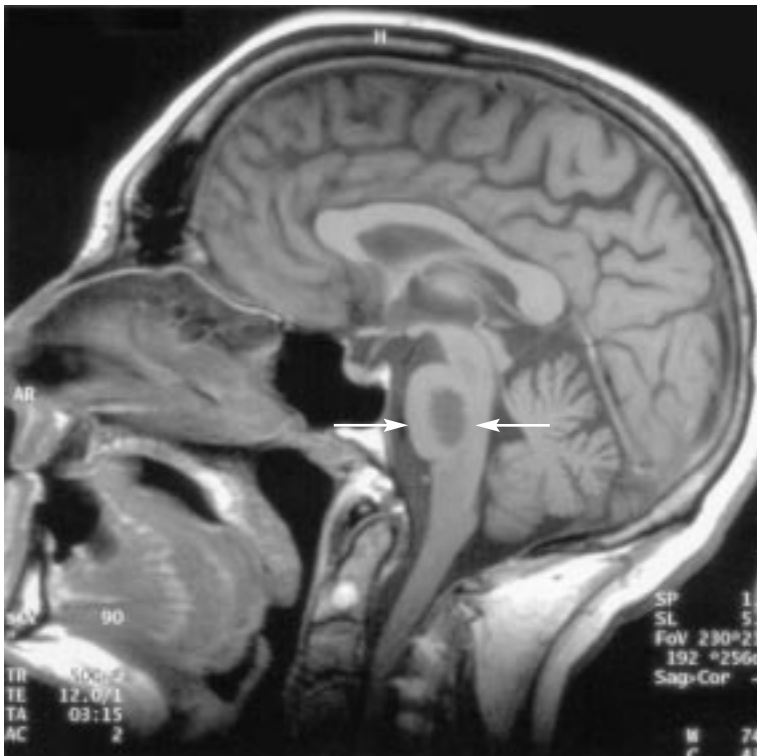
Magnetic resonance imaging scan, T1-weighted sagittal view, showing a hypointense area in the pons (arrows).
